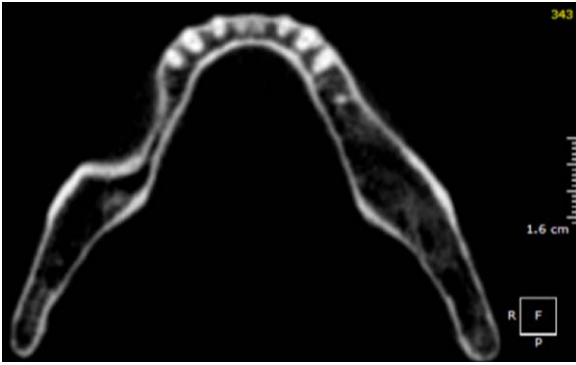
CBCT Scan before horizontal augmentation.
